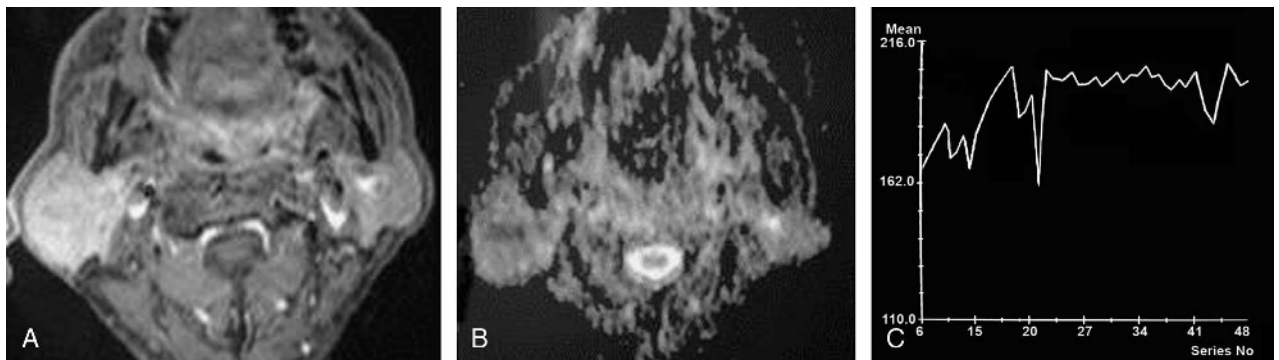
Warthin tumor. A, Axial contrast T1-weighted image shows enhancing soft tissue mass involving the superficial lobe of the right parotid gland. B, Axial ADC map shows restricted diffusion of the lesion with ADC value of $0.94 \times 10^{-3} \text{ mm}^2/\text{s}$. C, Time signal intensity curve shows the DSC% of the parotid tumor is 21.2%.
